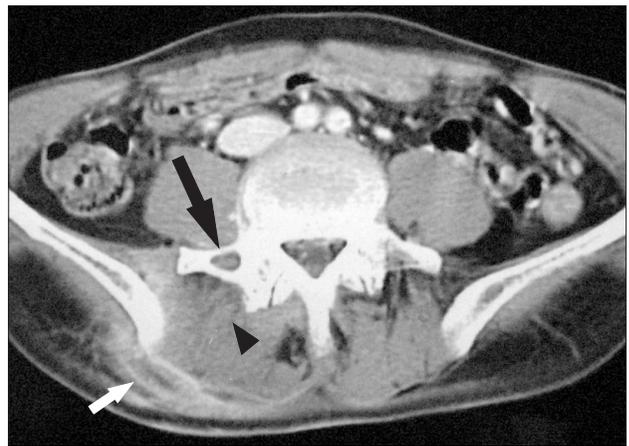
Axial enhanced computed tomography (CT) reveals a space-occupying lesion that showed a rim enhancement pattern (white arrow) and swelling and signal change of the paraspinal muscle (arrow-head). CT also reveals a 2 × 1 cm sized osteolytic lesion (black arrow) located in the right transverse process of L5.
